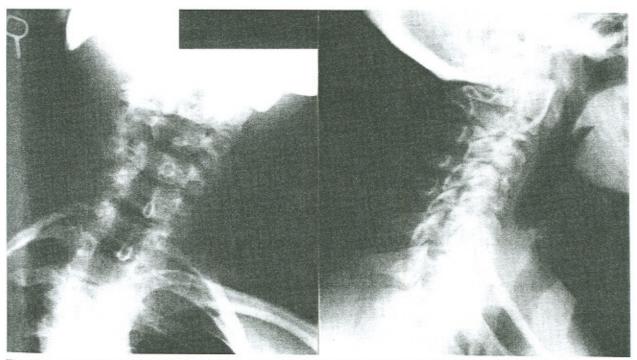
The anteroposterior and lateral cervical radiographic views shows tilting of the cervical spine to the left and degenerative changes involving the lower levels.
